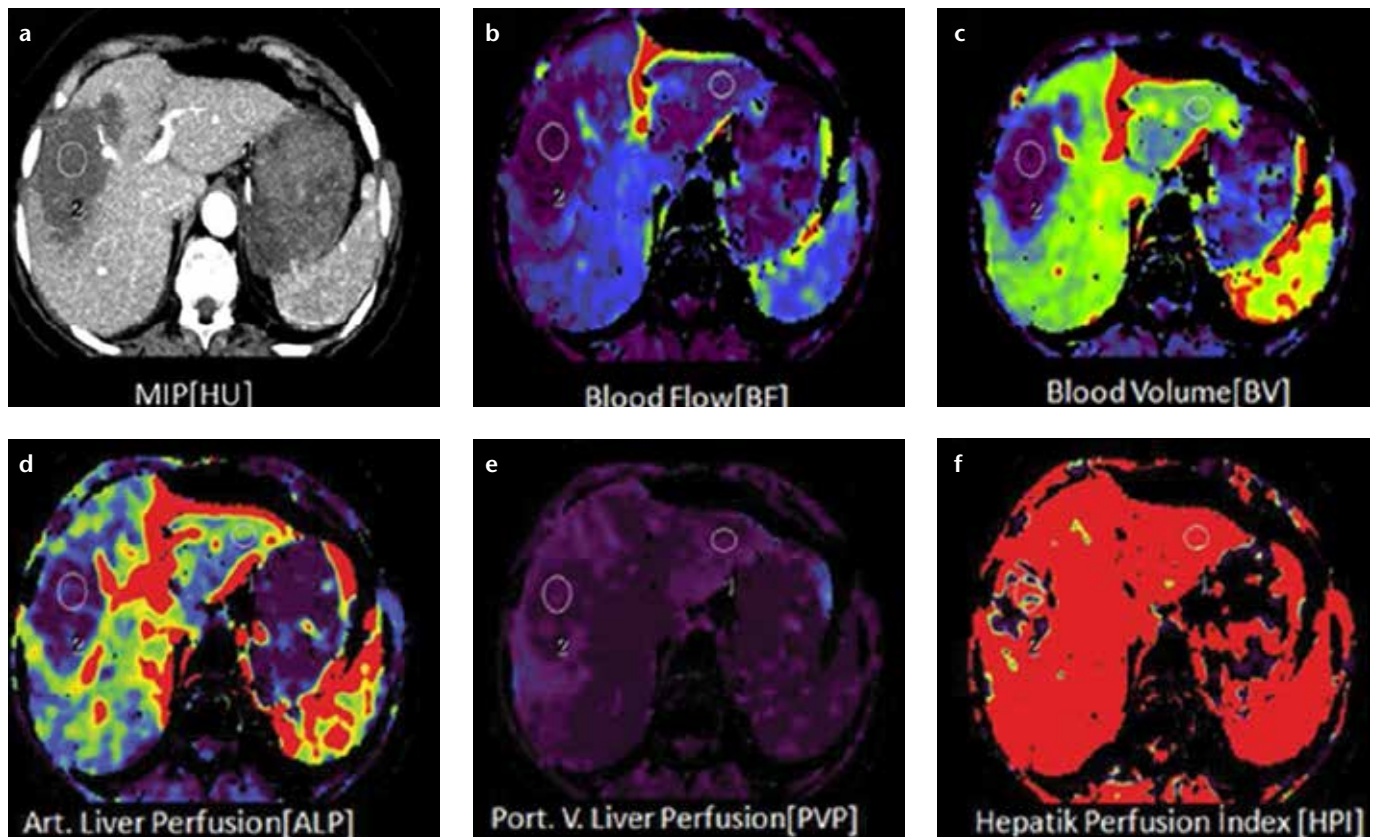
a–f. Axial perfusion images (a) and functional CT perfusion map (b–f) of a 29-year-old man with alveolar echinococcosis. The lesion shows a decreased hepatic arterial perfusion compared with the normal parenchyma.
